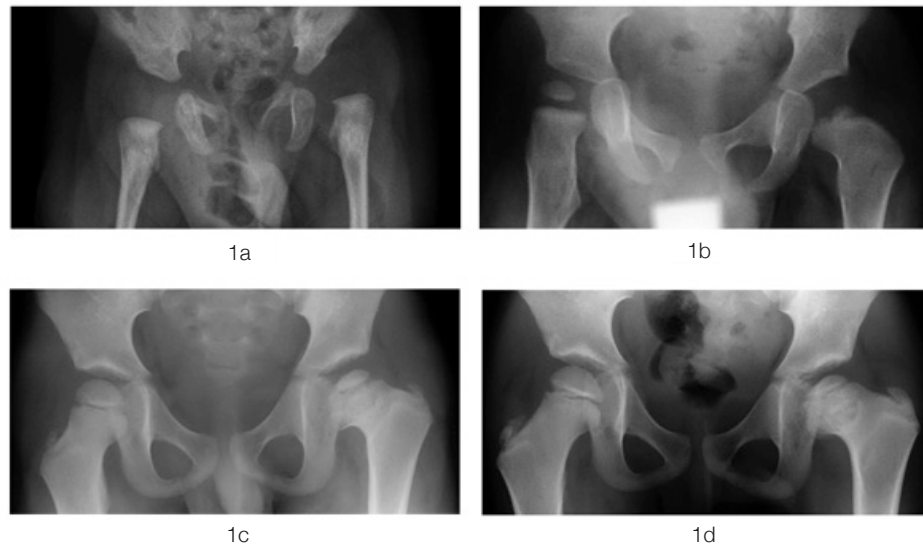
a) An antero-posterior radiograph of a four-month-old boy with dysplasia and dislocation of the left hip. b) One year after open reduction, there is type IV avascular necrosis of the femoral head. c) Significant growth disturbance of the medial plate is seen five years after treatment, leading to coxa vara. d) At 6.5 years after surgery, there remains coxa vara and the greater trochanter is starting to overgrow. The right hip is developing normally.
